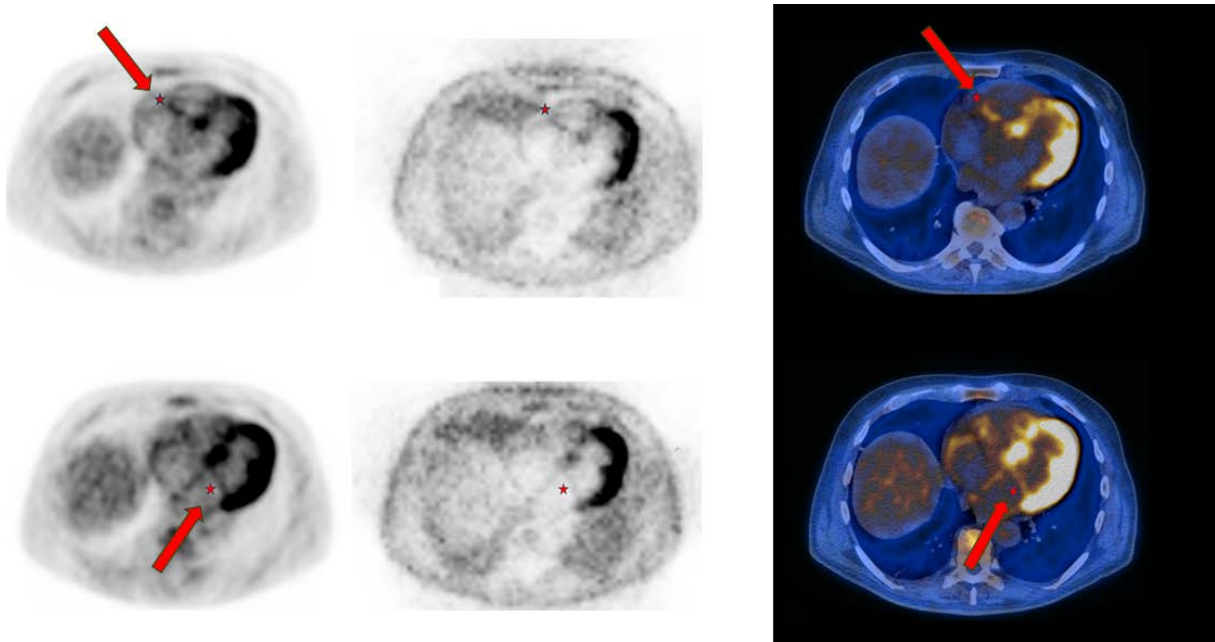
A. Axial ^{18}F -FDG PET/CT scans. Physiological tracer uptake in the myocardium - scan for oncological indications without dietary myocardial suppression. There is also a visible accumulation of tracer in the muscle of both atria as an expression of their overload. Upper row: apparent pathological focal tracer uptake at the native tricuspid valve site (indicated by an arrow and red asterisk). Lower row: faint uptake at the mitral valve site. From left to right: axial PET images with attenuation correction, axial PET images without attenuation correction (NAC), hybrid axial PET-CT scan
